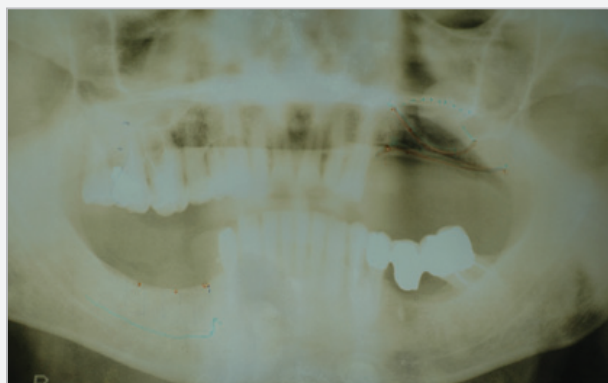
Case 1 - Preoperative x-ray. Note the reduced bone height above the mental foramen.
